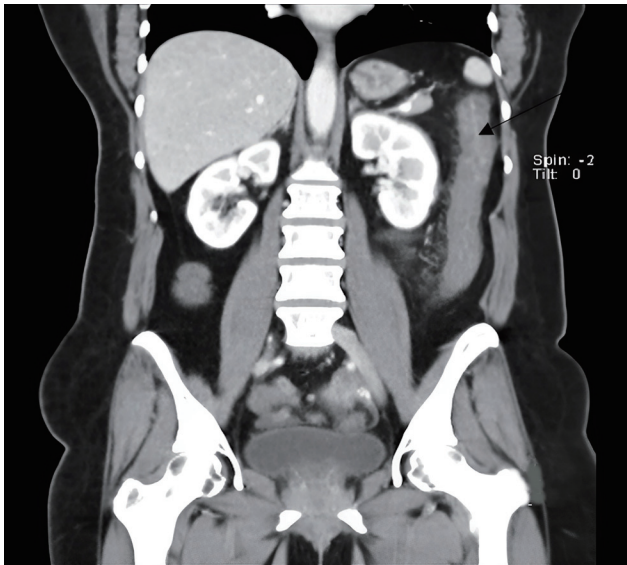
Computed tomography enterography on coronal section, revealing inflammation in the descending colon (black arrow).
